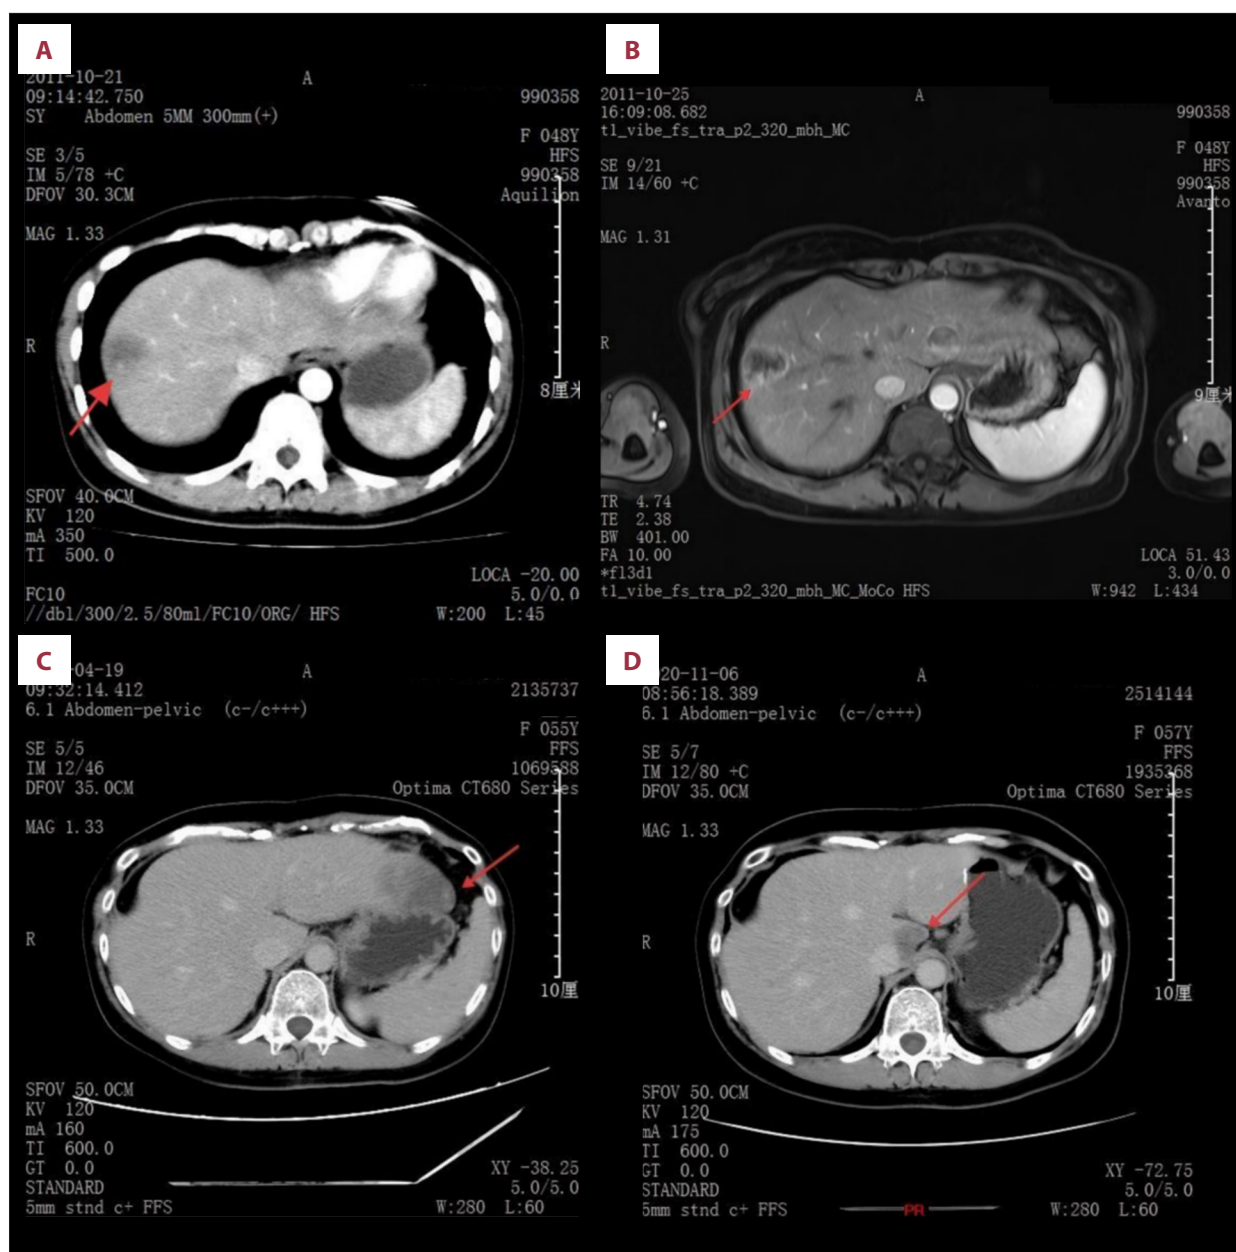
Preoperative abdominal imaging findings from the 3 surgeries of the patient. (A) Contrast-enhanced abdominal computed tomography (CT) scan in 2011 shows a mass-like low-density shadow (approximately 26 × 24 mm) in the anterior superior segment of the right hepatic lobe, with blurred margins, mild peripheral enhancement after contrast, and reduced size on the delayed phase. (B) Contrast-enhanced abdominal magnetic resonance imaging (MRI) scan (4 days later) reveals a clumpy abnormal signal focus (approximately 29 × 31 mm) in the anterior superior segment of the right hepatic lobe, exhibiting low signal intensity on T1-weighted imaging, high signal intensity on T2-weighted imaging, slightly high signal on diffusion-weighted imaging, early peripheral enhancement after contrast, and significant size reduction on the delayed phase. (C) Contrast-enhanced abdominal CT scan in April 2018 demonstrates a low-density nodule (approximately 34 × 52 mm) in the left hepatic lobe, with clear boundaries, nodular mild peripheral enhancement on the delayed phase, and reduction in lesion size. (D) Contrast-enhanced abdominal CT scan in November 2020 shows an oval, slightly low-density focus (approximately 21 × 23 mm) in the caudate lobe, with mild enhancement. Red arrows indicate the tumor locations.
